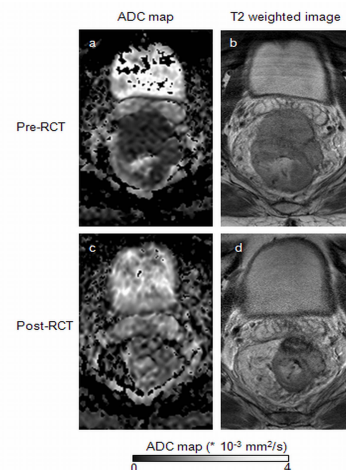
ADC maps T2w MRI images of a patient with locally advanced rectal cancer before and after RCT.
